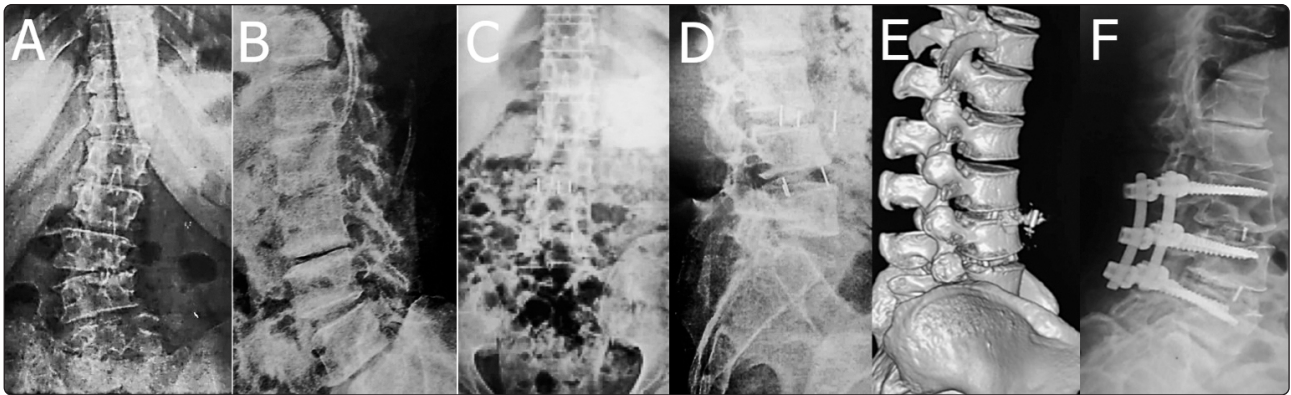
A 31-year-old male patient complaining of back pain and leg pain for 24 months. (A) AP X-ray L/S spine with degenerative scoliosis L3/L4 and L4/L5 and Cobb angle's was 21 degrees. (B) Lat. X-ray L/S spine with lumbar spine decreased lordosis and degenerative pattern in L3/L4 disc and LL was 10. (C) AP X-ray L/S after the first session shows improved Cobb's angle to 4 degrees. (D) Lat. X-ray L/S spine shows L3/L4 cage dislodgement and stable L4/L5 cage. (E) CT 3D reconstruction. (F) Lat. X-ray L/S spine shows posterior instrumentation and cage reapplication anteriorly.
